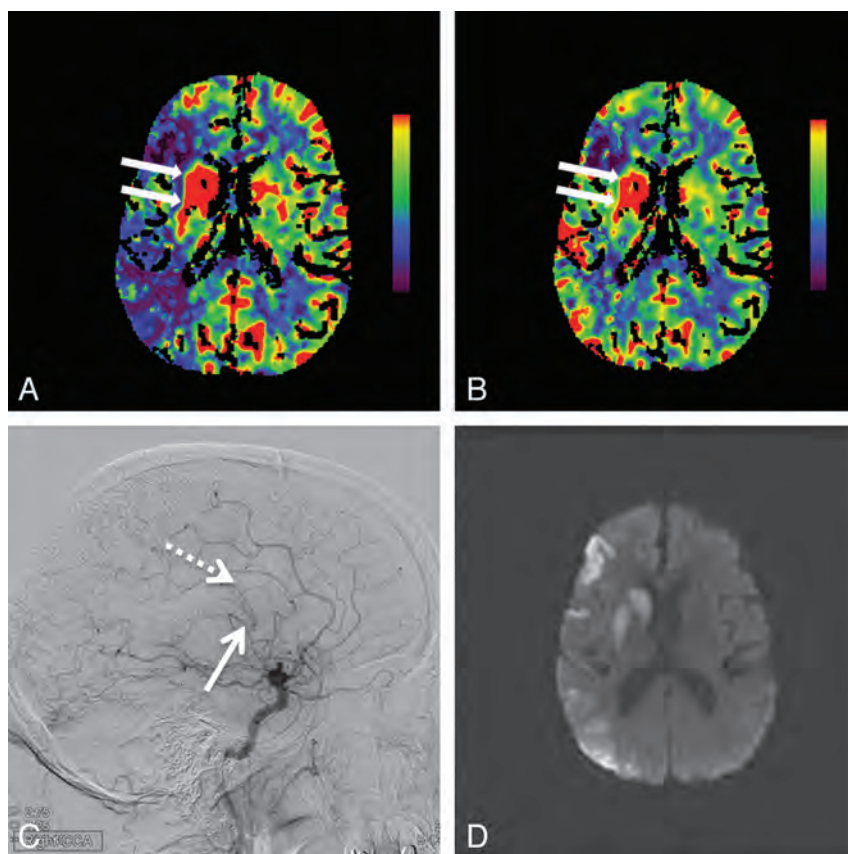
Hyperperfusion in the right basal ganglia is demonstrated by increased cerebral blood flow (arrows, A) and increased cerebral blood volume (arrows, B). Also seen is a large region of right middle cerebral artery territory ischemia as evidenced by reduced CBF (A) with relative preservation of CBV (B). Lateral digital subtraction angiogram from a right carotid artery injection demonstrates early opacification of the basal vein of Rosenthal (solid arrow, C) and the internal cerebral vein (dashed arrow, C). Follow-up MR imaging 12 hours later shows restricted diffusion indicating infarction of the right basal ganglia, along with patchy cortical infarctions in the right MCA territory (D).
